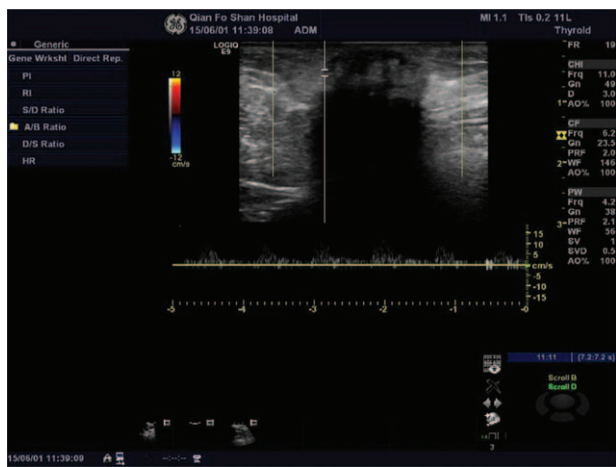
CDFI showing arterial blood flow signals at the edge of the hypoechoic group. CDFI= color Doppler flow imaging, GCT=granular cell tumor.
